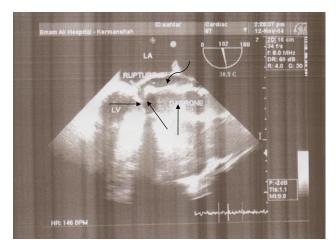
Transesophageal echocardiogram clearly showing Dacron tube (vertical arrow), the orifice of ruptured pseudoaneurism (oblique arrow), and prosthetic aortic valve (transverse arrow), ruptured space (curved arrow), and left ventricle (LV) marked with arrow.
